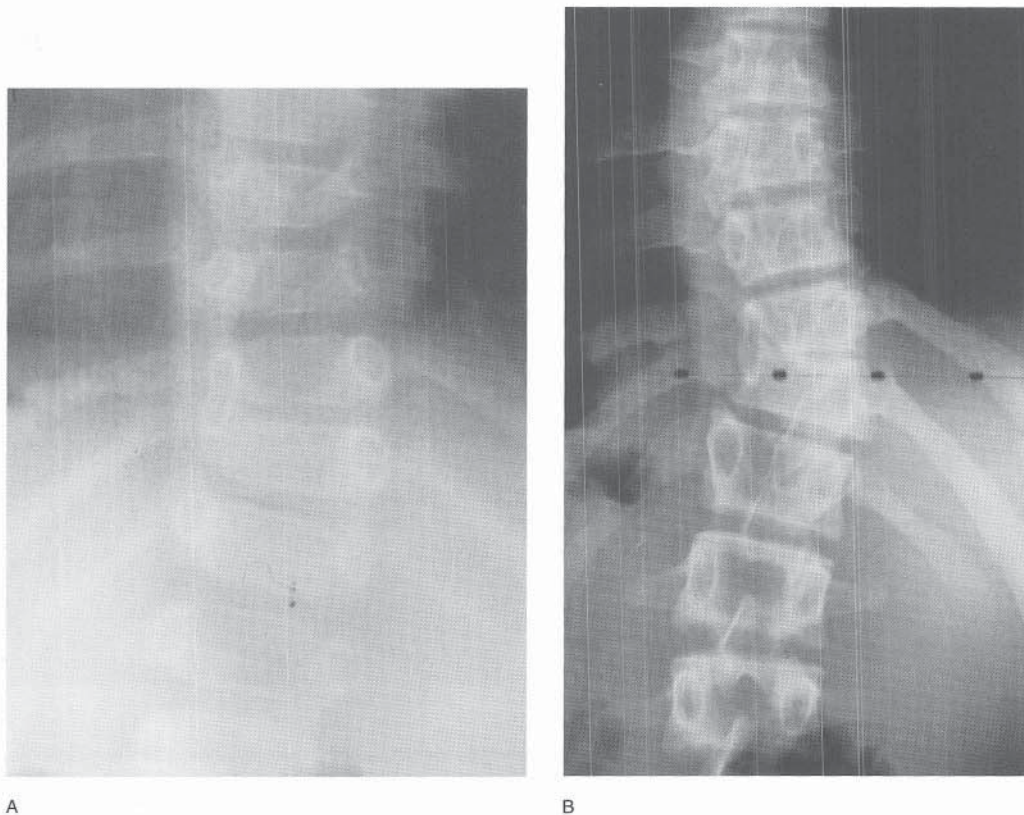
An 11-month-old boy had a unilateral failure of segmentation noted on a radiograph obtained because of mild back asymmetry (A). On a radiograph obtained at age 16 years, no significant change had occurred in the spinal alignment, even though no intervention had been undertaken (B).
